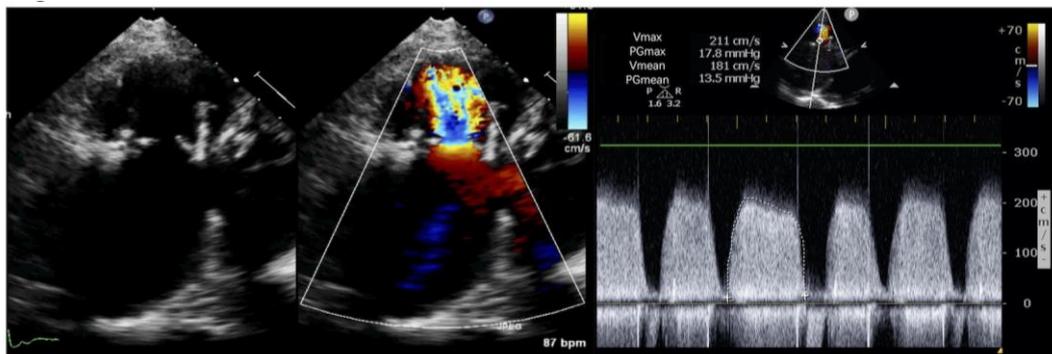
Emergency bedside transthoracic echocardiography prior to decannulation revealed severe stenosis of the tricuspid prosthesis, leading to flow acceleration. The apical four-chamber view is shown.
